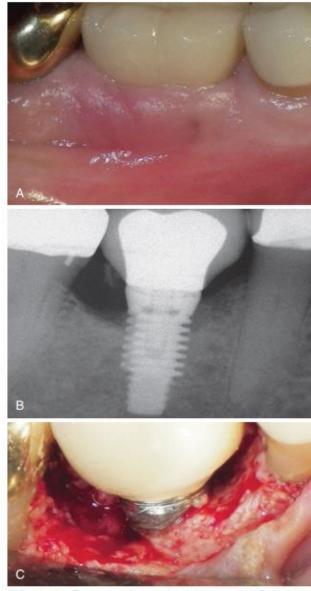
Treatment for retained cement. (A) Soft tissue irritation with chronic inflammation. (B) Radiographic confirmation of retained cement. (C) Treatment included surgical access for cement removal that included curettage, detoxification, and grafting.
